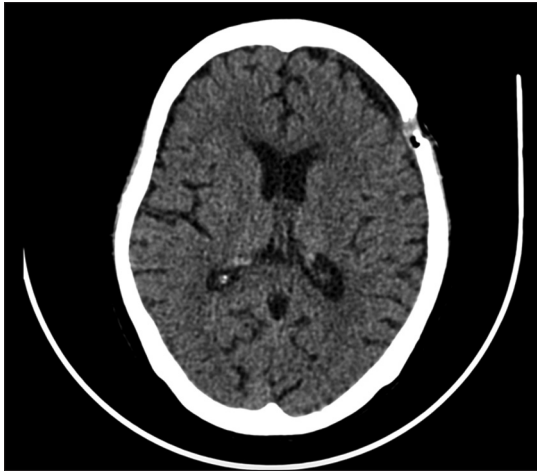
Computed tomography scan during the 1-month follow-up. Bone defect could be seen. Hematoma decreased to minimum level
